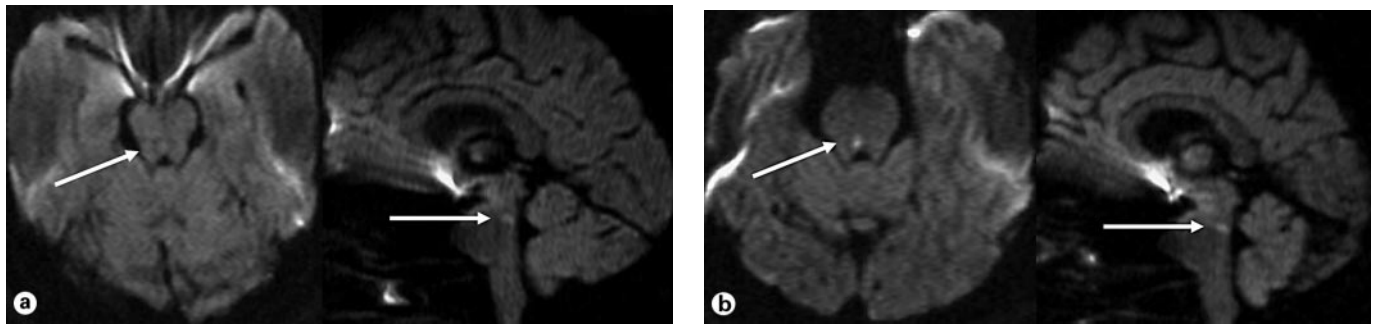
DWI of patient 17 with initial DWI ($b = 1,000 \text{ s/mm}^2$) displaying the ischemic lesion only clearly on the sagittal plane and follow-up DWI confirming the infarction in both planes (arrows indicating ischemia). a Axial and sagittal plane performed 19.5 h after symptom onset. b Axial and sagittal plane performed 36 h after symptom onset.
